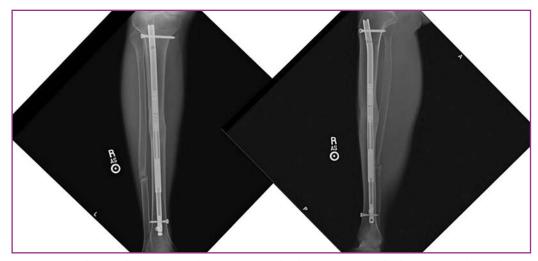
Radiographic images after removing the loose proximal locking screw from the superior and inferior tibiofibular joints.
